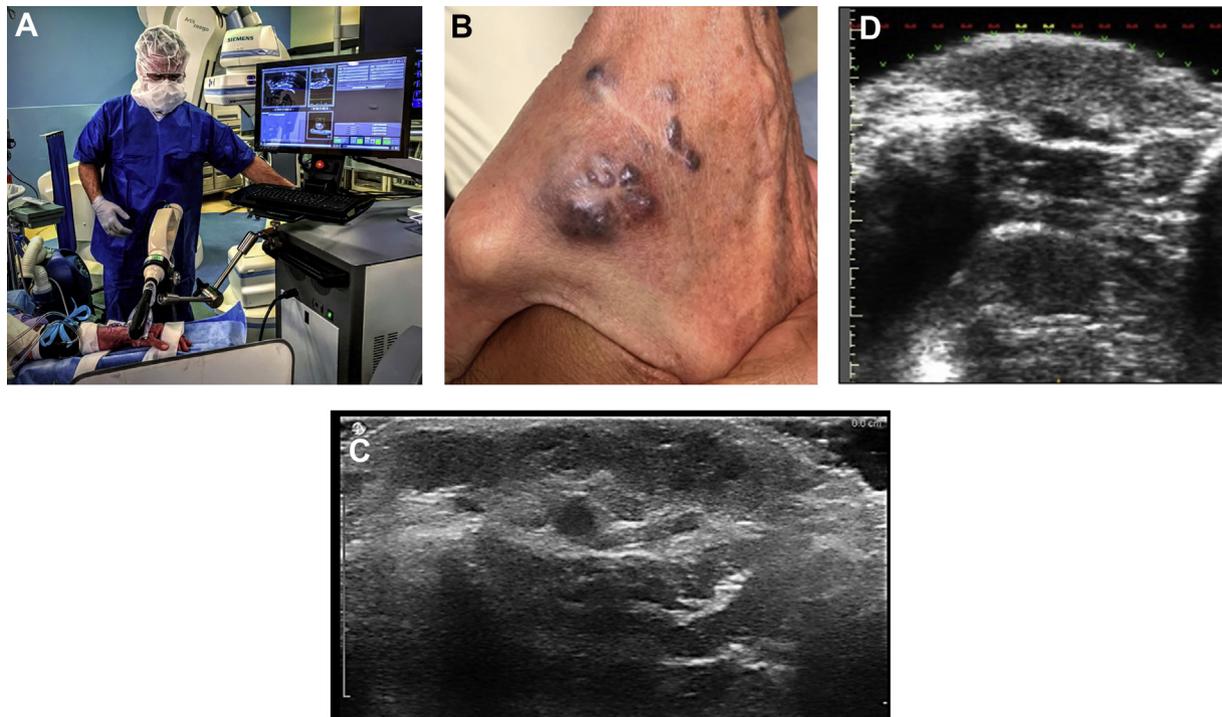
A, Demonstration of Sonablate high-intensity focused ultrasound (HIFU) probe placement using the adjustable probe arm and associated software and the program used for scanning and imaging the targeted region of the body. This is the platform via which HIFU treatment planning and, ultimately, treatment delivery would be performed. B, Venous malformation (VM) on the dorsum of the left hand first web space in a patient with blue-rubber bleb nevus syndrome. Note the healed surgical incision from a previous failed attempt at excision. C, Preoperative diagnostic ultrasound (US) B-mode imaging of the same lesion. D, Sonablate probe B-mode US image demonstrating the outline, contour, borders, depth, and traversing anomalous vasculature of the same lesion.
